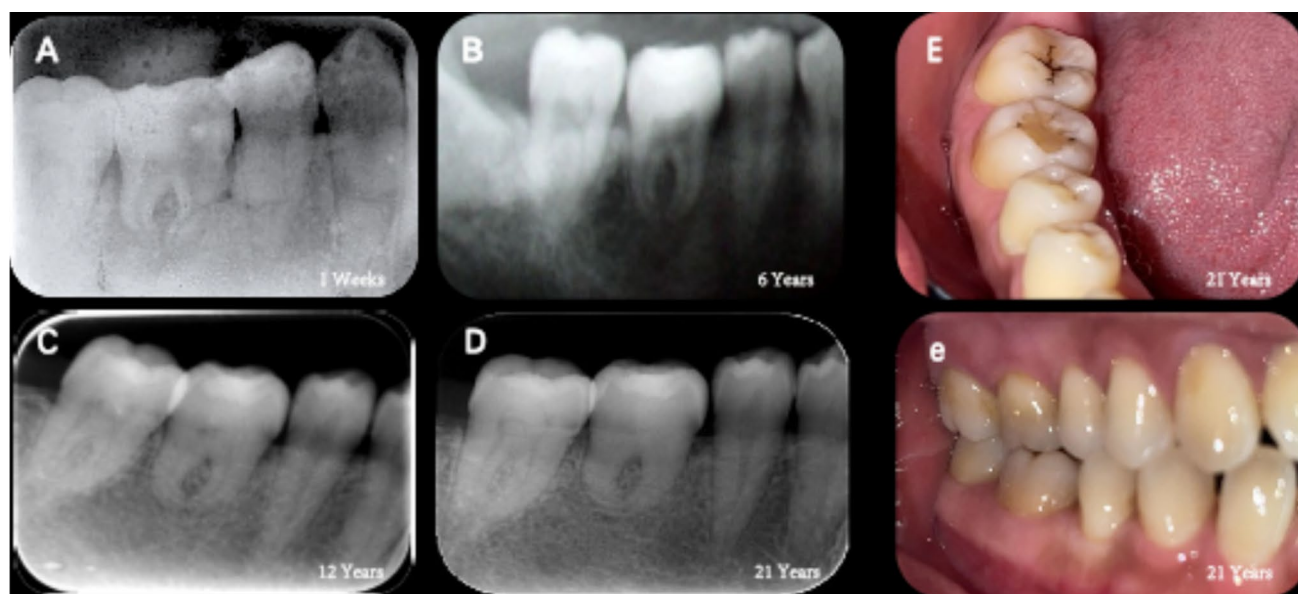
A one week postoperative (periapical dark shadows) (B) six years postoperative (apices not yet completely closed, continuous regular black translucent images surrounded the roots) (C) twelve years postoperative (apices completely closed, visible periapical space) (D)
